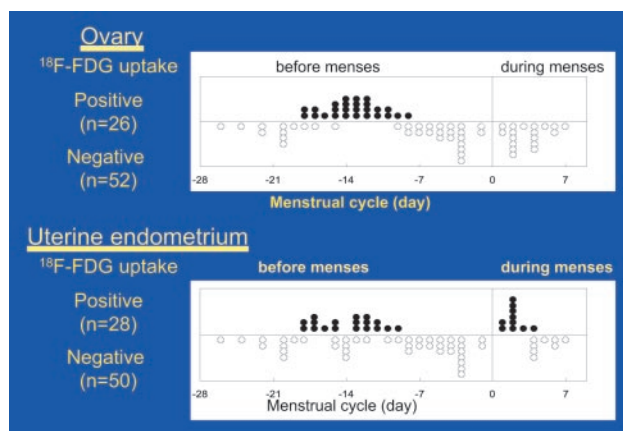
^{18}F -FDG uptake in the normal ovary and uterus in relation to the menstrual cycle.
